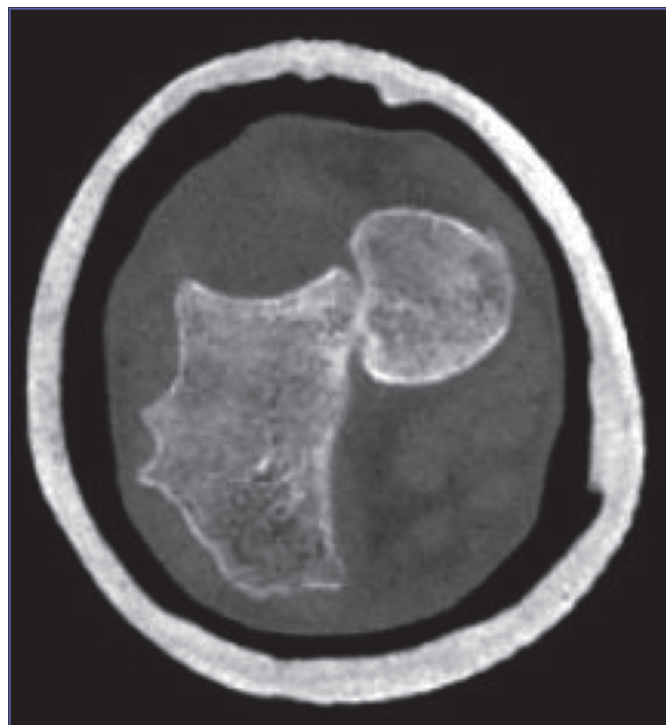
Absence of ulnar head in the ulnar notch: CT-scan examination.
